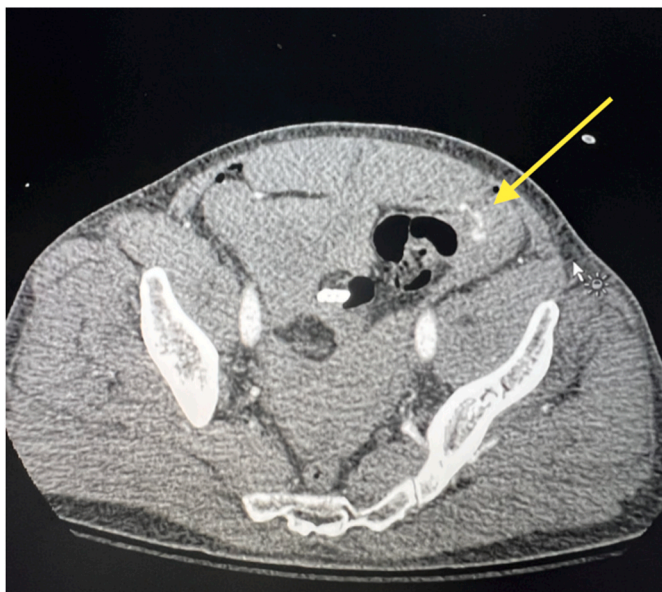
CT showing an active bleed along the left lower quadrant, consistent with inferior epigastric artery.
